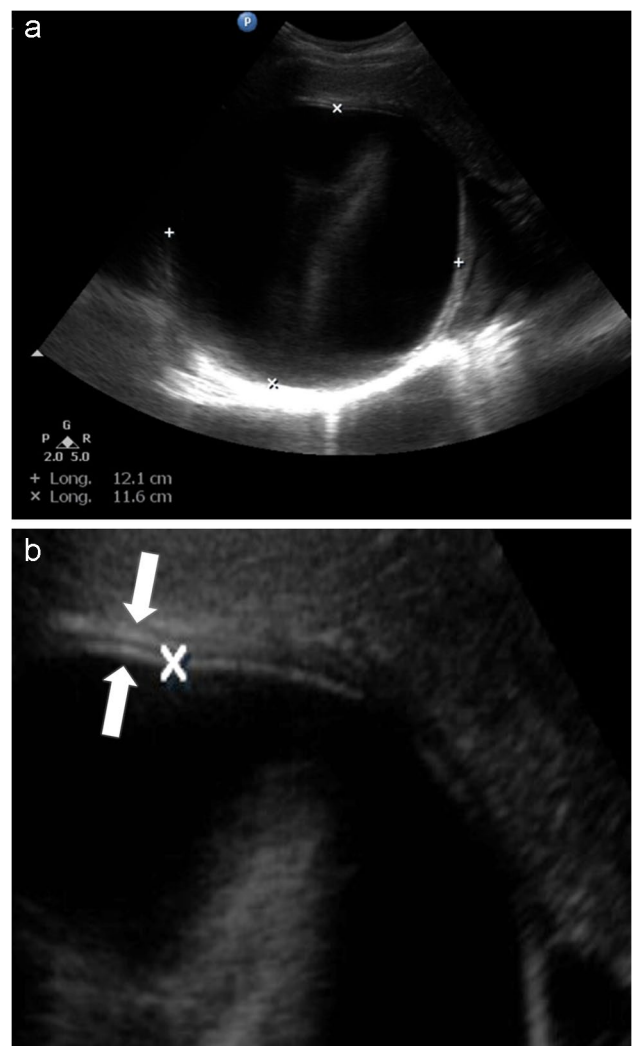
Hepatic hydatid disease in an 11-year-old girl from an endemic region. a Transverse abdominal ultrasound image shows a rounded, well-defined, unilocular cystic lesion (between calipers), classified as CE1—group 1 of WHO classification, Gharbi I. b Magnified ultrasound image to emphasize the components of the cyst wall, seen as “the double-line sign” (arrows)
